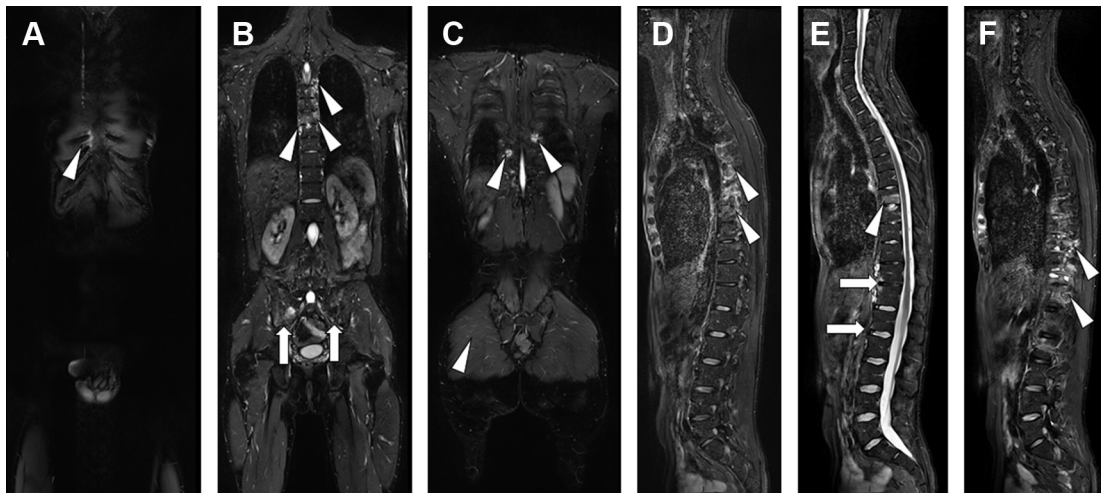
WB MR imaging from a 33-year-old male patient with AS. Anterior to posterior WB coronal short-tau inversion-recovery (STIR) MR imaging (A–C) shows extensive sacroiliac joint (SIJ) inflammation (arrows in B), along with chondrosternal joint (arrowhead in A), midthoracic vertebral endplates (arrowheads in B), and costovertebral (arrowheads in B and C) involvement. Sagittal STIR MR imaging (D–F) shows vertebral angle involvement at the thoracolumbar junction (arrows in E), extensive endplate involvement at the midthoracic level (arrowhead in E), and severe involvement (arrowheads in D and F) of the lateral portion of the vertebral endplates and costovertebral joints (arrowheads in D and F).
